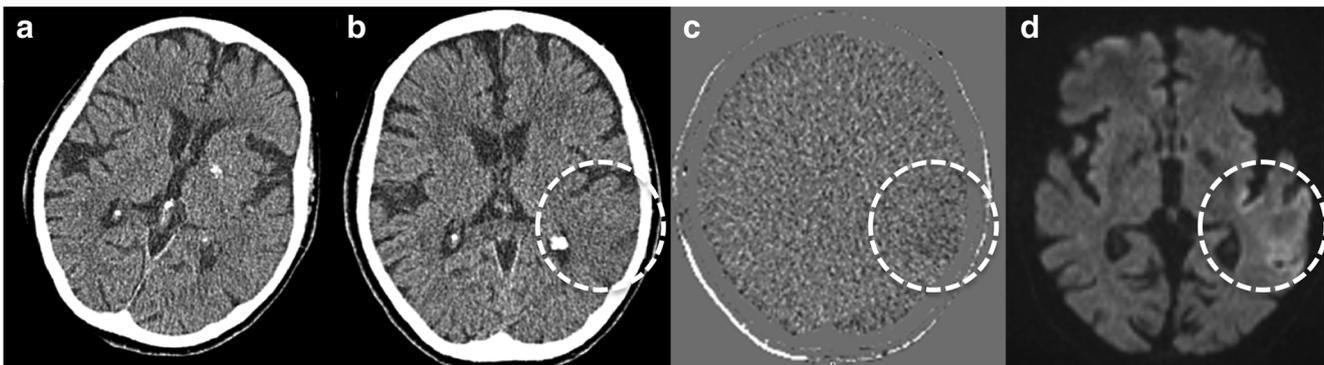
A case of a 78-year-old female with a fresh infarct in the left lateral lobe (dotted circle). From the left the (a) previous CT, (b) current CT, (c) TS CT and (d) DWI image ($B = 1000$) are shown. The lesion was correctly marked by 7.1% (1/14) of the readers without TS and 93% (13/14) with TS
